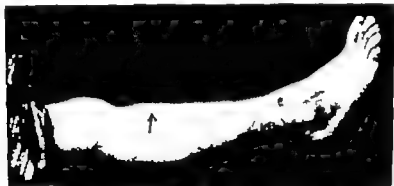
A typical localization for syphilitic secondary periostitis. The roentgen-ray examination is negative.
